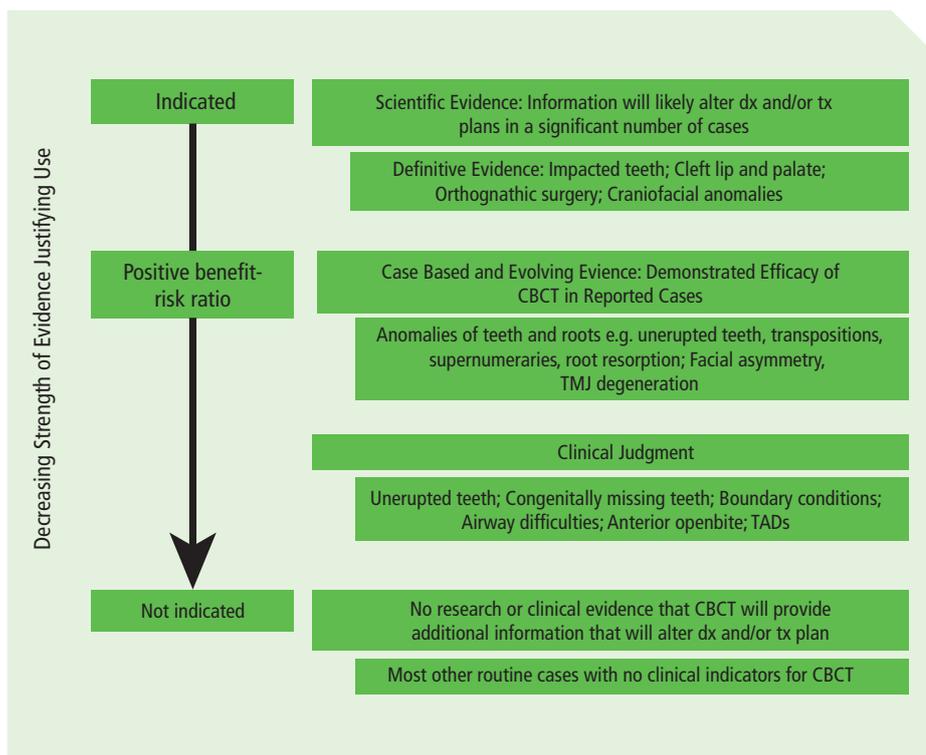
Clinical scenarios where CBCT may be indicated.²
